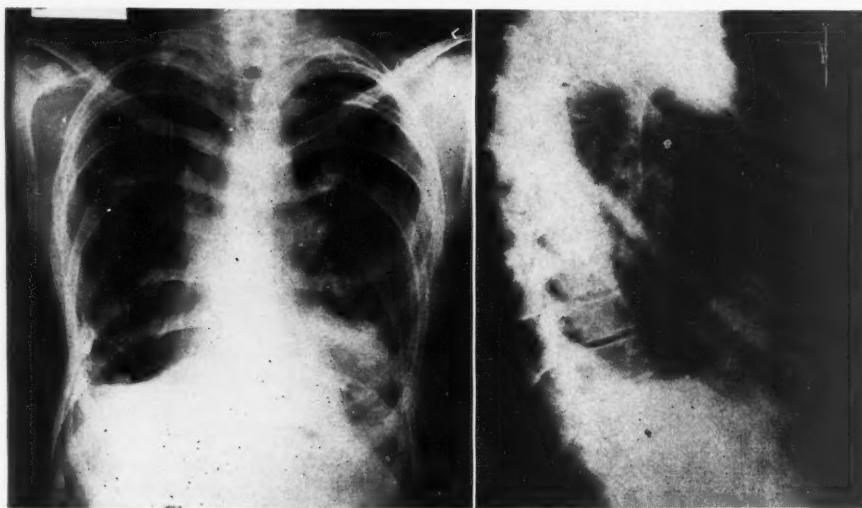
Roentgen-ray films taken in September 1948. Note the large A-V fistula in the lingual portion of the left upper lobe.
